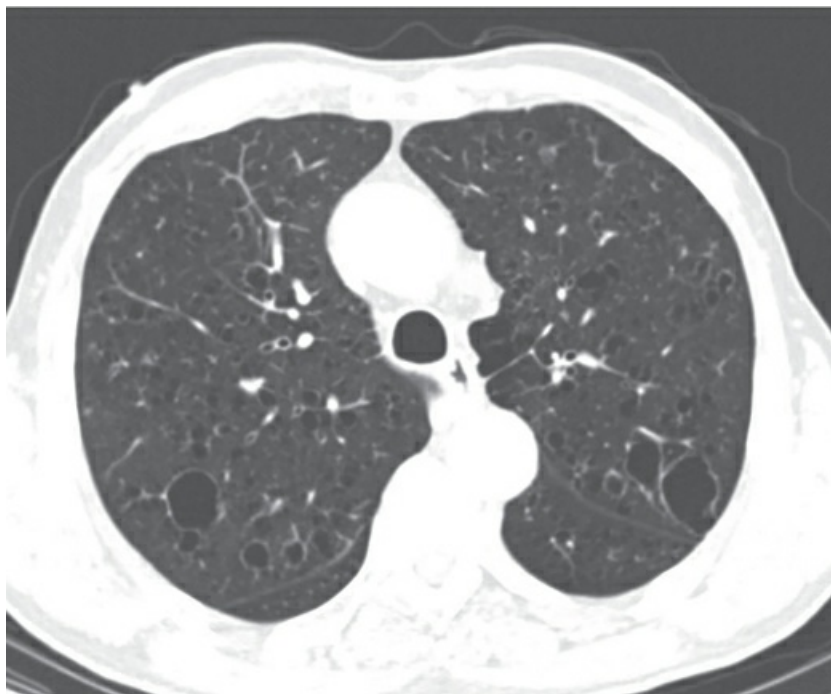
Chest CT scan demonstrates multiple cysts of variable size in a patient with pulmonary Langerhans cell
